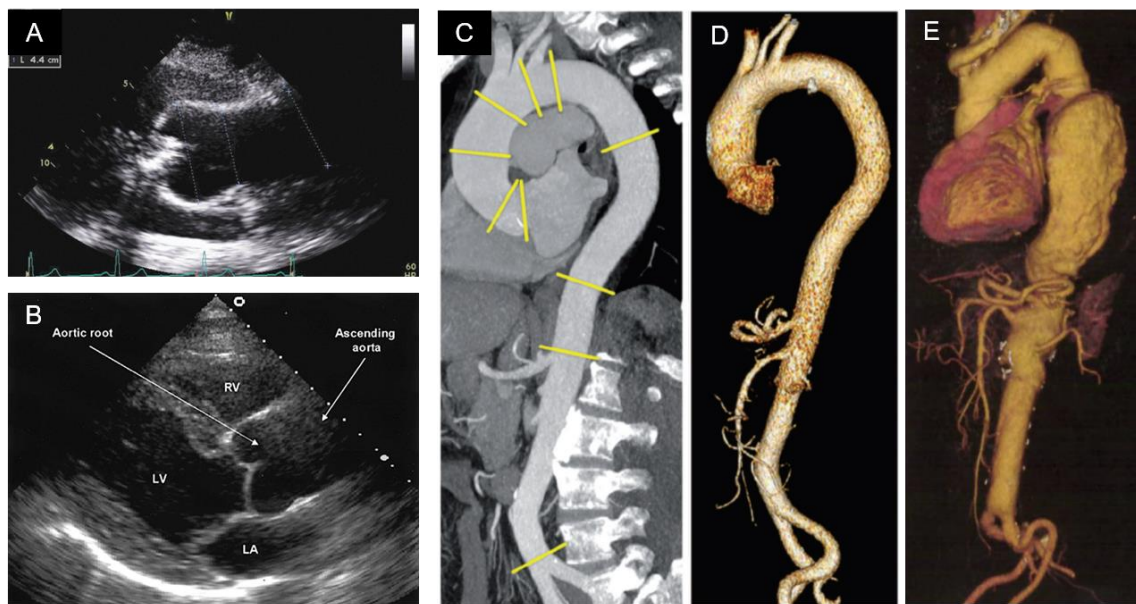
Diagnosis imaging of aortic aneurysms. A. Echocardiography of a healthy ascending aorta. B. Echocardiography of ascending aorta aneurysm. Note that the sinotubular junction, the border between the aortic root and the tubular ascending aorta, is no longer present. C. Slice of thorax CT, displaying the aorta, vertebrae, and other tissues<sup>26</sup>. D. 3D reconstruction of the aorta at the CT acquisition. E. 3D reconstruction of an aorta with a descending thoracic aneurysm. The heart is included in this reconstruction<sup>2</sup>.
